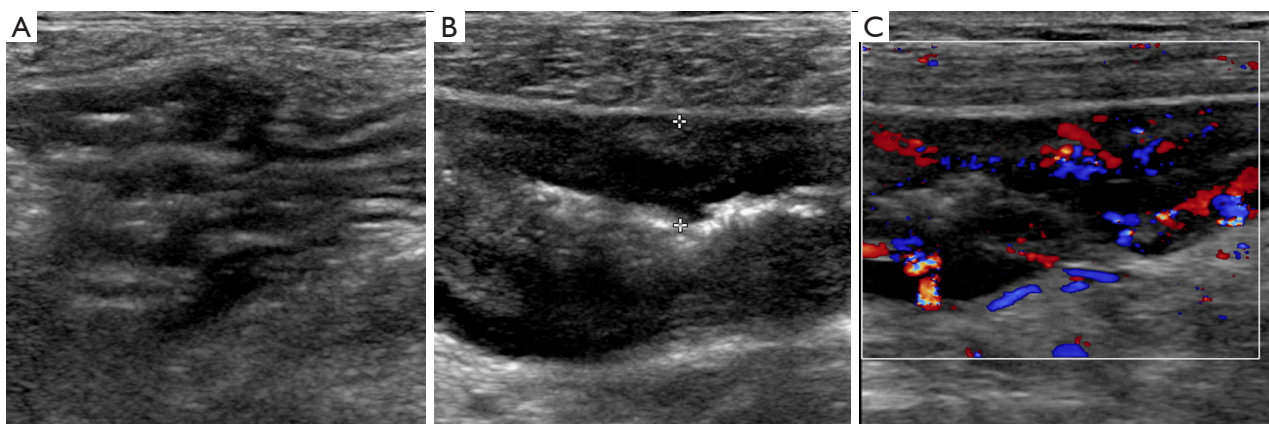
Representative intestinal ultrasound (IUS) images of Crohn's disease (CD). (A) Transverse view showing the thickened ileocecal valve and terminal ileum. (B) Longitudinal view of the fourth part of the small intestine showing the thickened bowel wall (between crosses). (C) Colored Doppler US image shows the long, rich stretches of vascularity into the mesentery.
